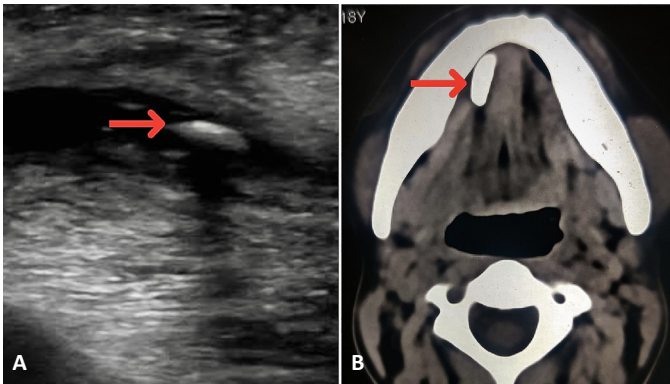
A. Sialoliths seen on ultrasonography with a dilated duct B. Sialolith seen in submandibular duct on CT scan
